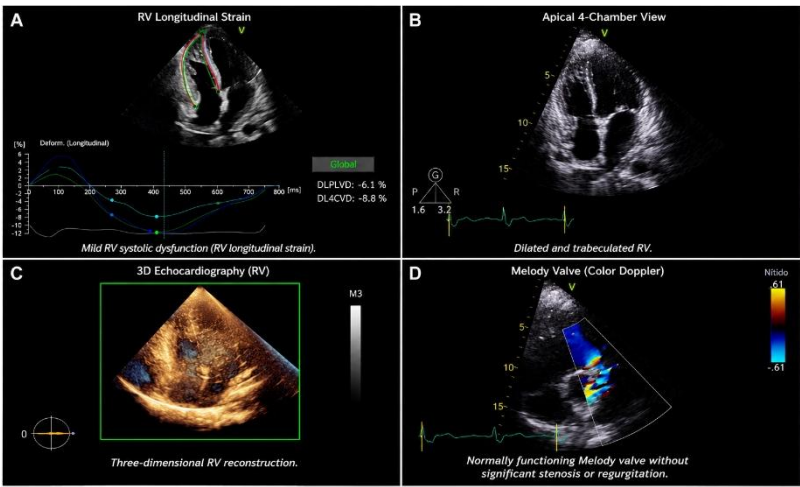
Transthoracic echocardiographic assessment during pregnancy in repaired tetralogy of Fallot after Melody valve-in-valve implantation. (A) Right ventricular (RV) longitudinal strain demonstrating mild RV systolic dysfunction. (B) Apical 4-chamber view showing dilated and trabeculated RV. (C) Three-dimensional RV reconstruction. (D) Color Doppler assessment of a normally functioning Melody valve without significant stenosis or regurgitation.
